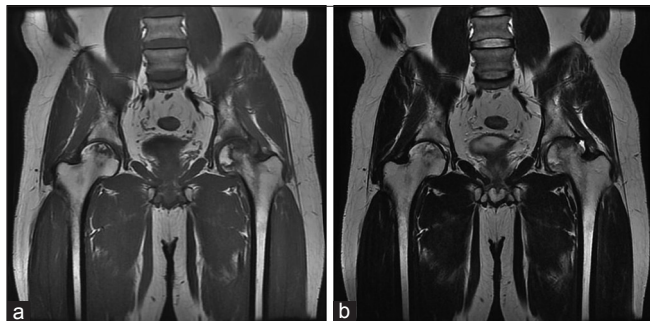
(Case 2) Magnetic resonance imaging of both hips showing avascular necrosis of both femoral heads (a) T1 coronal and (b) T2 coronal.
